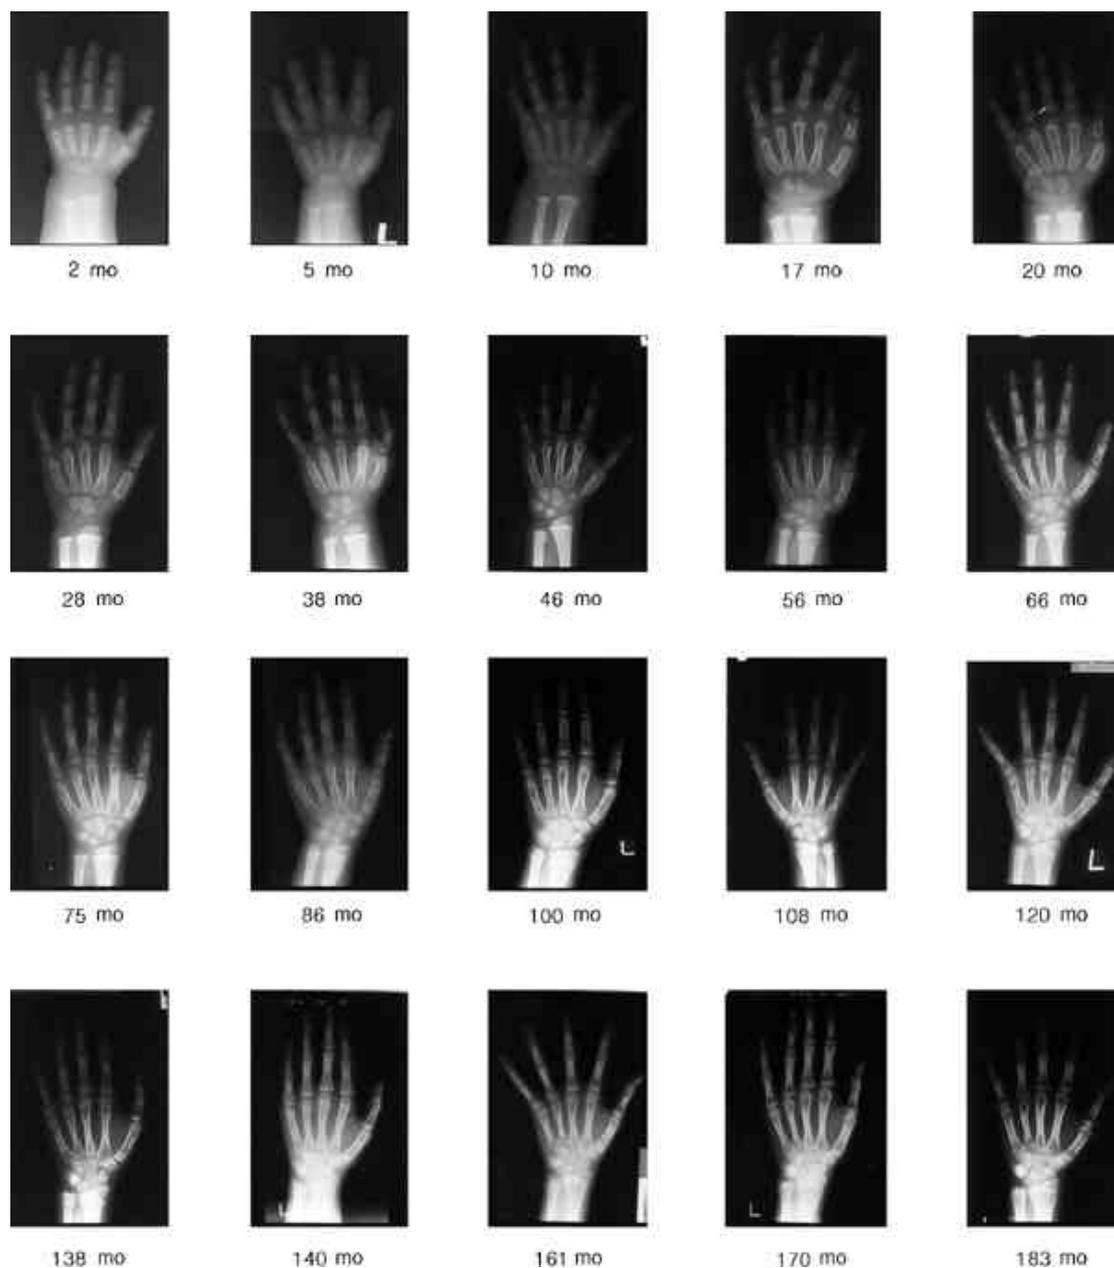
Hand Radiographs for the Representative Ages (Female)
